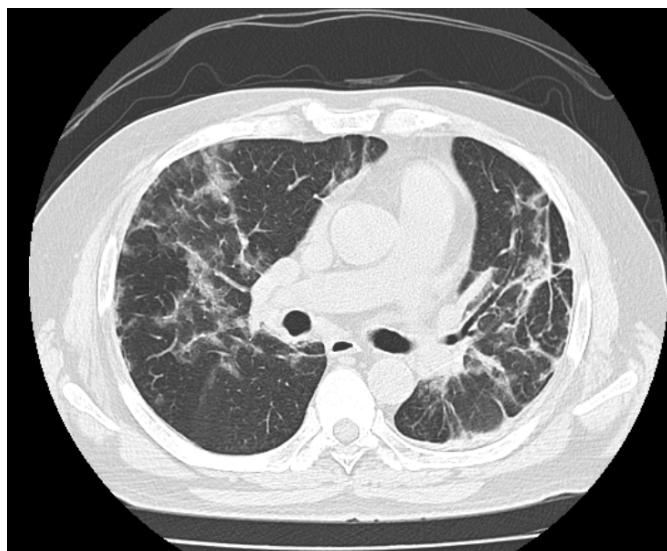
Image Courtesy: 5c Network | Vardhman CT Scan Center
